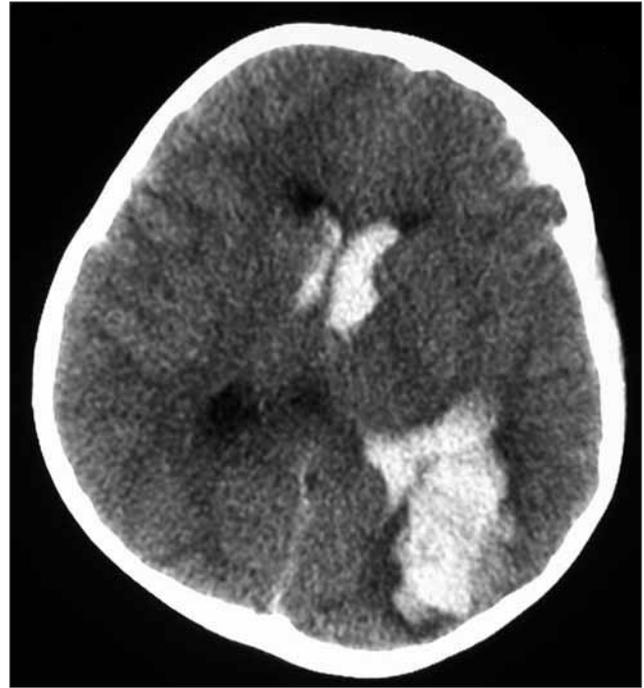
Computed tomography demonstrating an acute intra-cerebral hematoma measuring 4x4 cm and opening to the ventricular system at the left parieto-occipital region.
